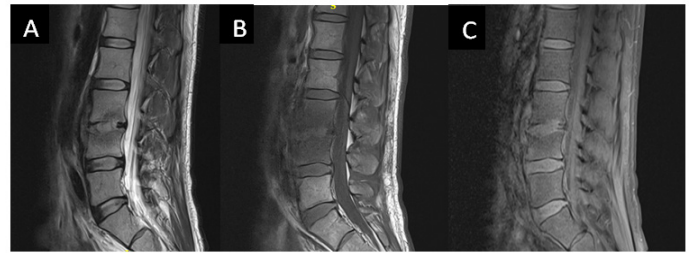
Spine MRI. The initial MRI showed a high T2 signal (fluid) in the L3-L4 disc space (A) and a high T2 signal/low T1 signal in adjacent end plates (bone marrow edema, B) with concomitant loss of low-signal cortex at the end plates and contrast enhancement (C).
